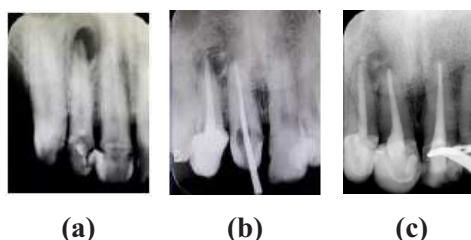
(a)Pre-operative radiograph. (b) Radiograph showing 1 month follow-up post application of MTA plug. (c) Radiograph showing 4 months follow-up post application of MTA plug.
